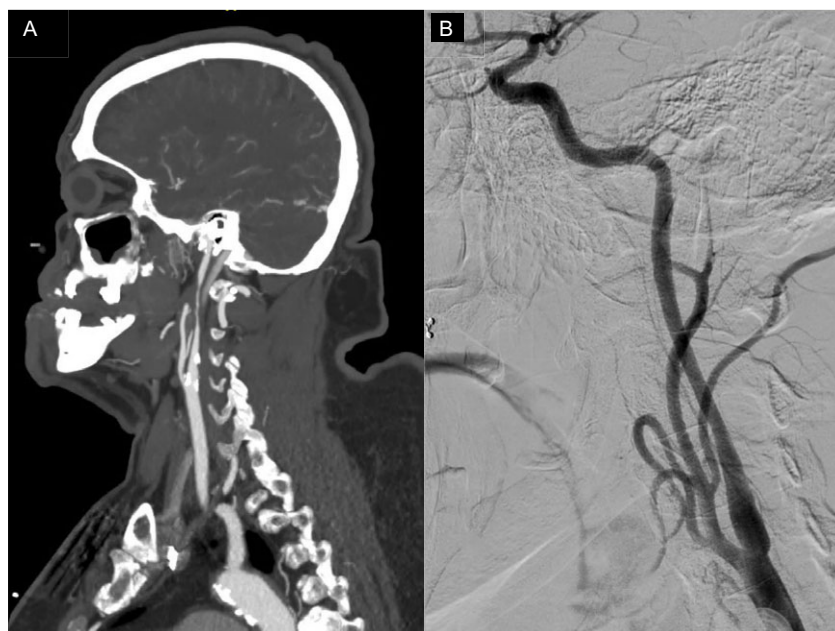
Imaging of patient presenting with blurring of vision in the left eye and weakness of the right leg in January 2023. (a) Cranial CT/CT angiogram showing worsening left internal carotid artery (ICA) stenosis. (b) Cerebral angiogram showing resolution of the left ICA stenosis.
